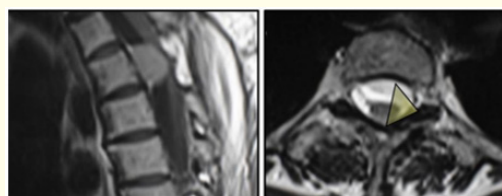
Sagittal contrast enhanced T1 (left) and axial T2 (right) weighted MRI sections show a ventral meningioma with contrast enhancement. The anterolateral triangle represents the possible safe trajectory for surgical exposure of the tumor.
